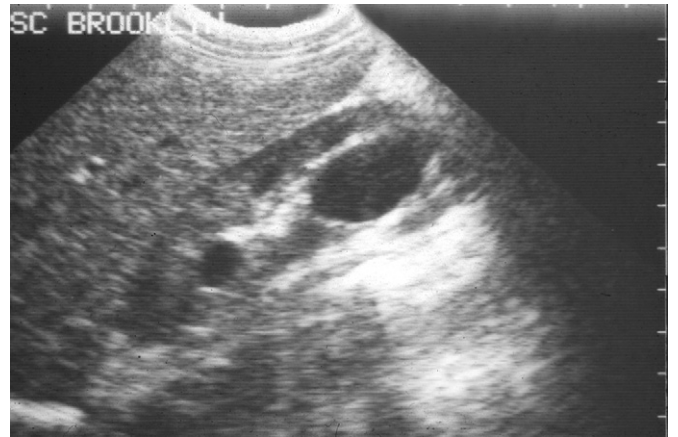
Two simple renal cysts in a 7-year-old. Note the whiteness (hyperechogenicity) just outside the kidney on ultrasonography. This is referred to as acoustic enhancement, a finding typical of simple cysts. It occurs secondary to increased sound wave reverberation through the cyst, and it interfaces with the kidney. It is important not to confuse this finding with an atypical, asymmetric presentation of autosomal dominant polycystic kidney disease.
